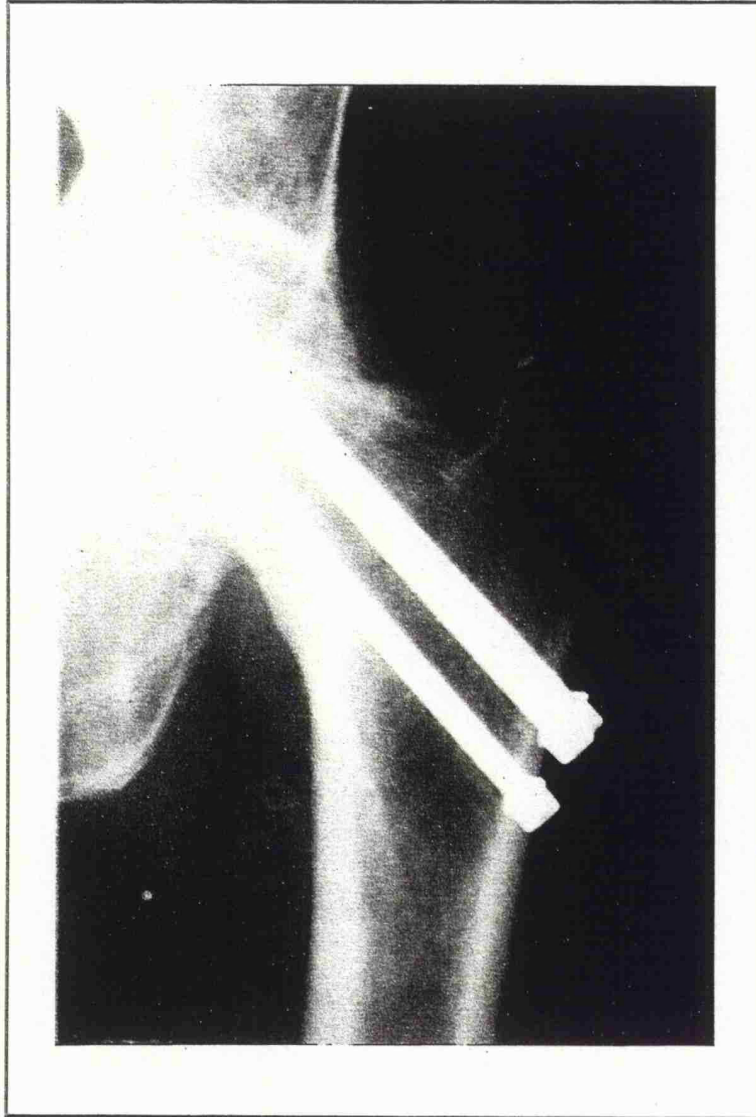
Lateral radiograph showing position of Ambi hip screw.
